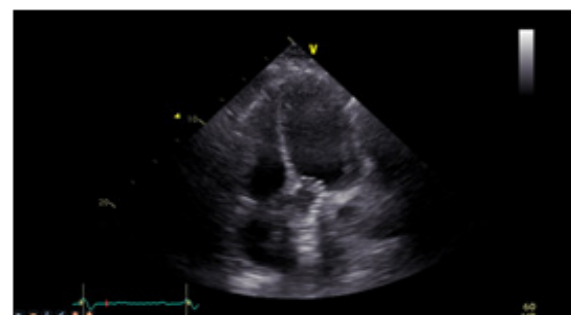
LV 2D-Echocardiography recorded in five chambers approach showing transcatheter aortic valve implantation (TAVI) on the aortic valve.
